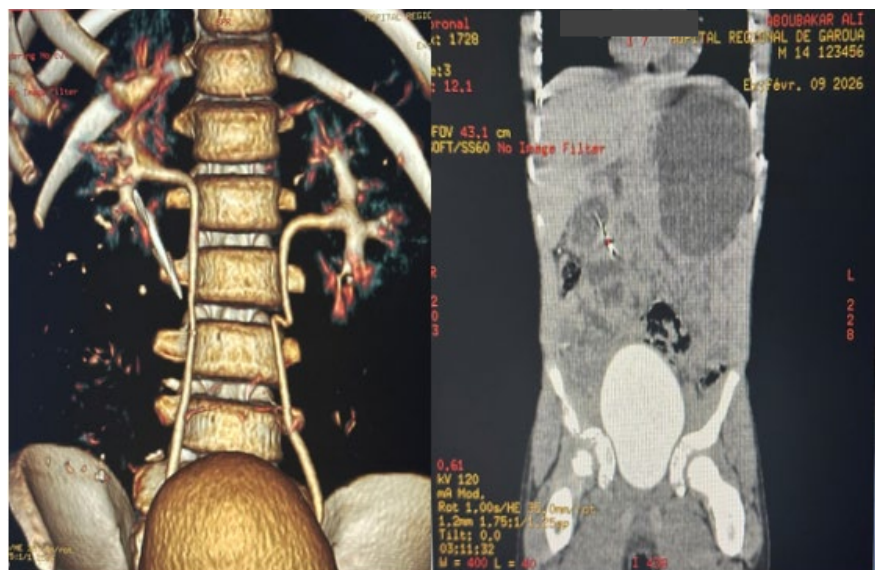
Abdominal CT-scan showing a linear hyperdense image at the right upper quadrant.
